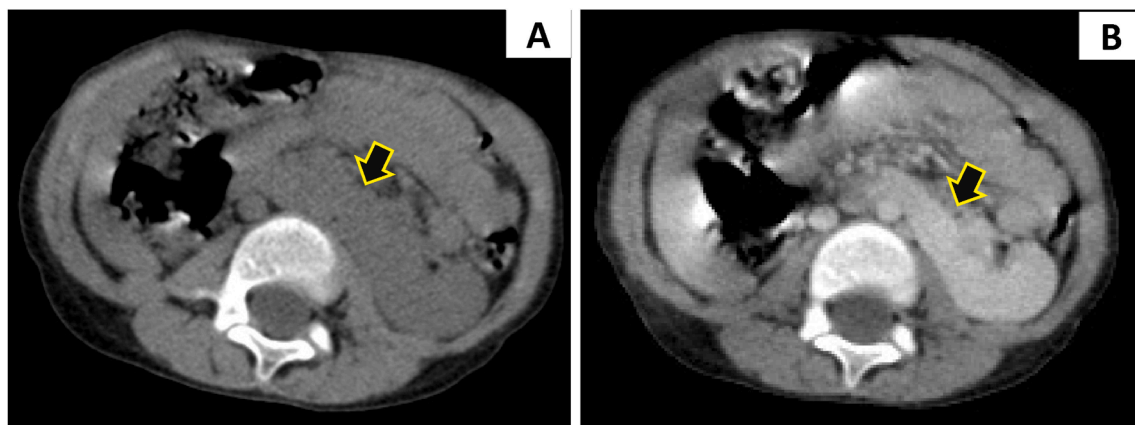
(A): is an axial non-enhanced computed tomography (CT), (B): is an axial enhanced CT, showing a crossed fused ectopic left kidney (arrows).
